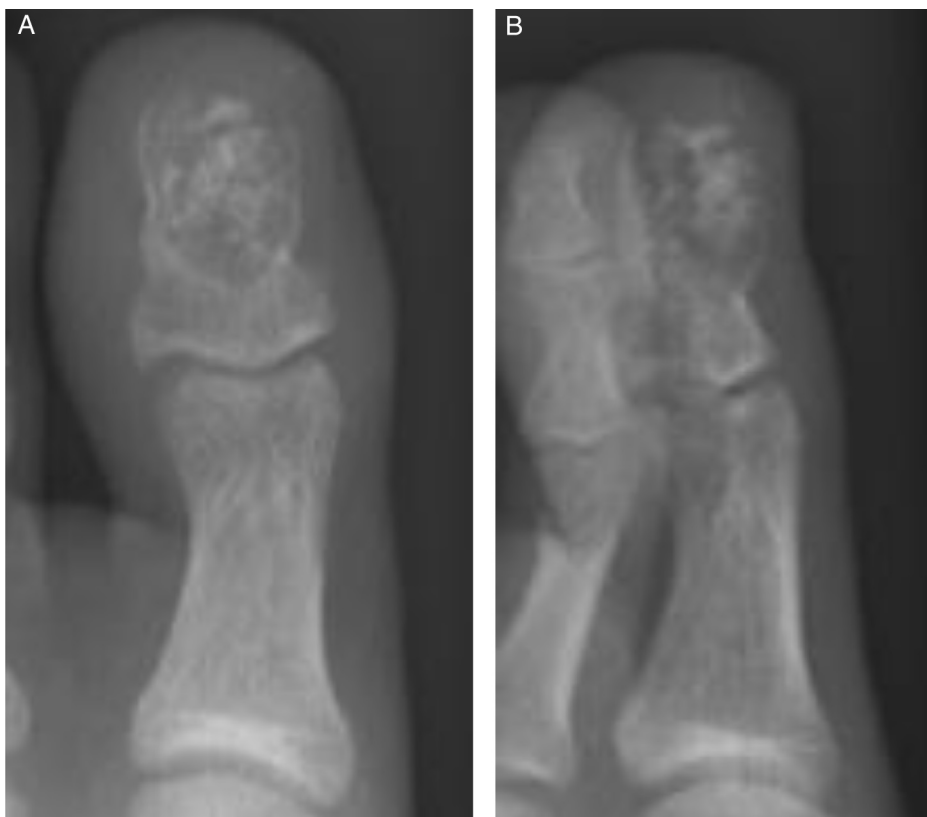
(A and B) Radiographs after surgery showing allograft grafted into the cavity.
